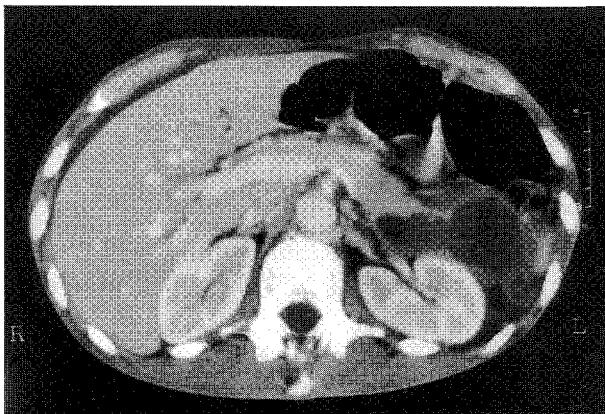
Contrast enhanced computed tomography (CT) showing pancreatic pseudocyst and normal liver morphology in a patient with SLE before treatment.
